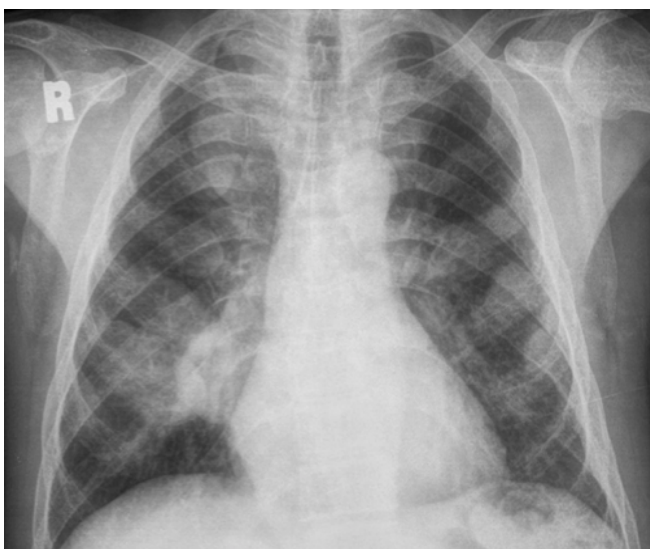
PA chest x-ray showing multiple homogeneous density increments and not obliterating the cardiac contours.
